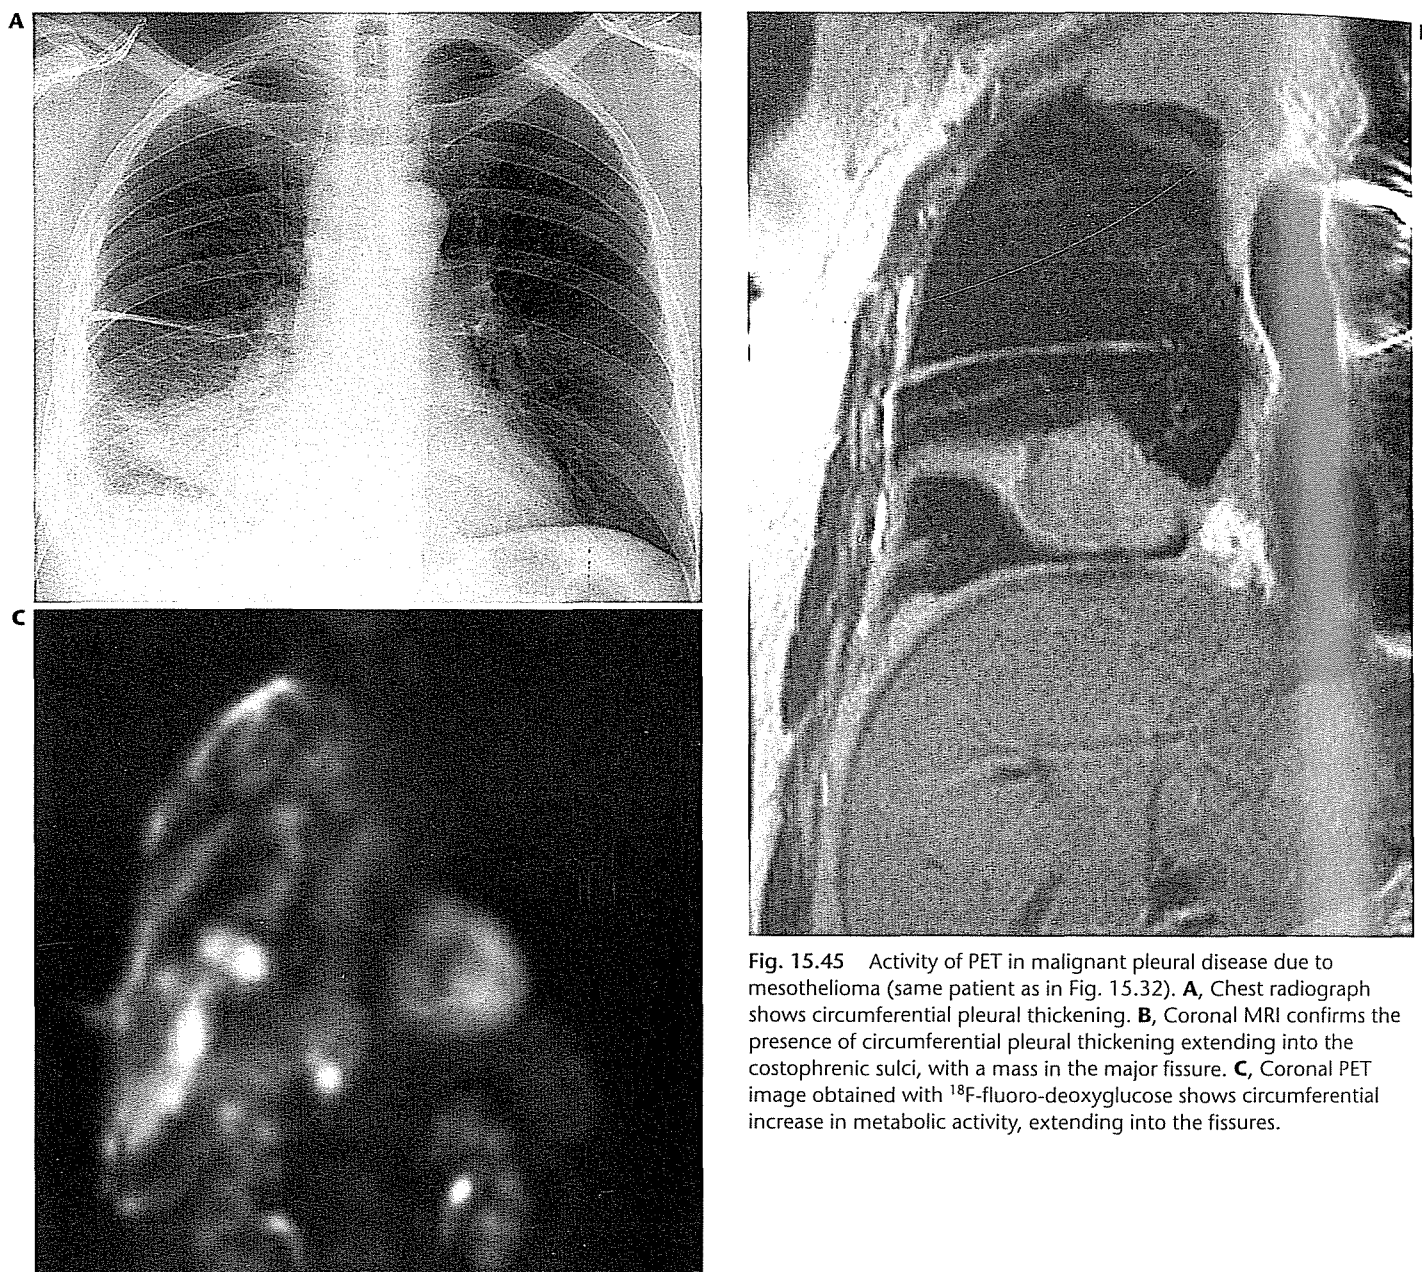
Activity of PET in malignant pleural disease due to mesothelioma (same patient as in Fig. 15.32). A, Chest radiograph shows circumferential pleural thickening. B, Coronal MRI confirms the presence of circumferential pleural thickening extending into the costophrenic sulci, with a mass in the major fissure. C, Coronal PET image obtained with ^{18}F -fluoro-deoxyglucose shows circumferential increase in metabolic activity, extending into the fissures.
